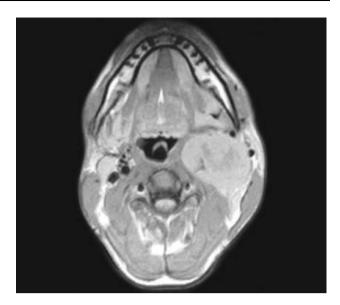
MR angiography T1-weighted axial section image showing vagal schwannoma occupying left carotid space
